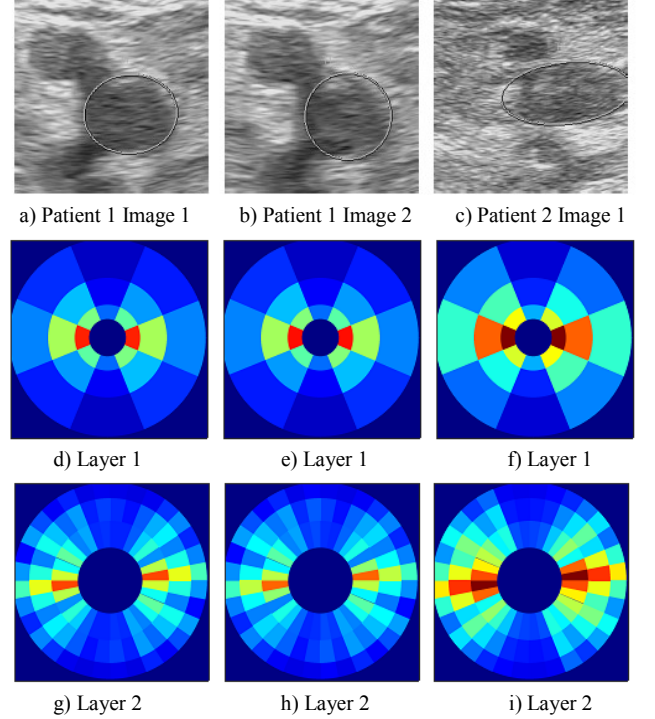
Three ultrasound images taken from two different patients (the blood clots are encircled); the first and the second layers of the scattering coefficients are represented in the frequency plane.
